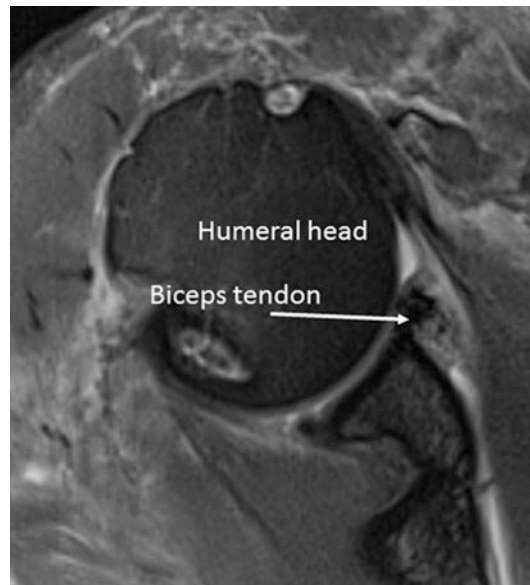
Coronal view of the right shoulder MRI 6 months after the surgery shows good healing of biceps tendon and transformation to neolabrum
